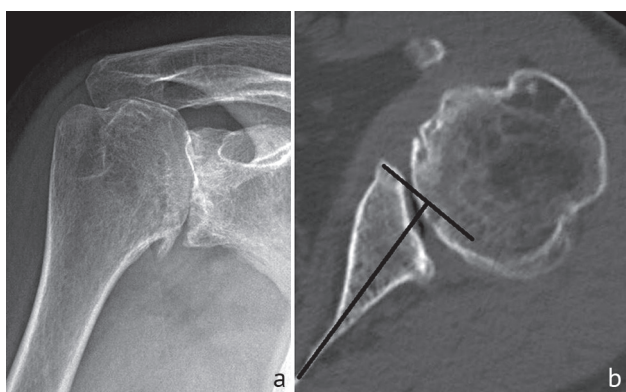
Images of the shoulder joint: a standard anteroposterior radiograph; b axial CT scan of the same shoulder joint
